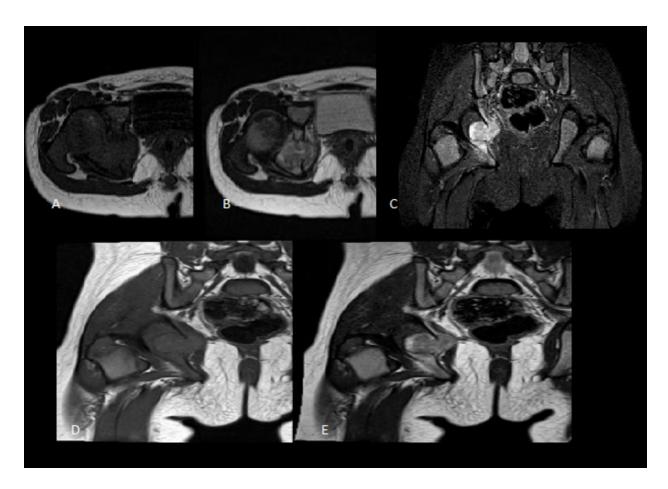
Eosinophilic granuloma. This lesion presents with low intensity of signal on T1-weighted images (A,D) and slightly heterogeneous hyperintensity signal on T2-weighted images (B,E). There is bone marrow and surrounding muscle oedema (C).
